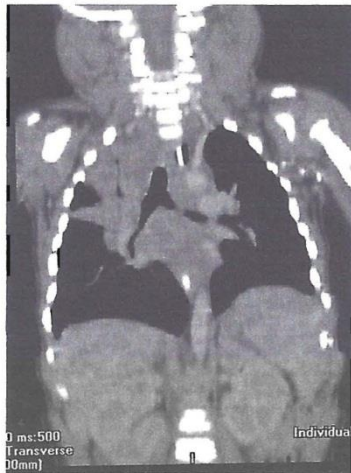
Coronal reconstruction of a CT scan of the chest demonstrating compression of the left and right main bronchi by enlarged tuberculous lymph nodes. The importance of the enlarged subcarinal nodes in the airway compression is clearly demonstrated.
